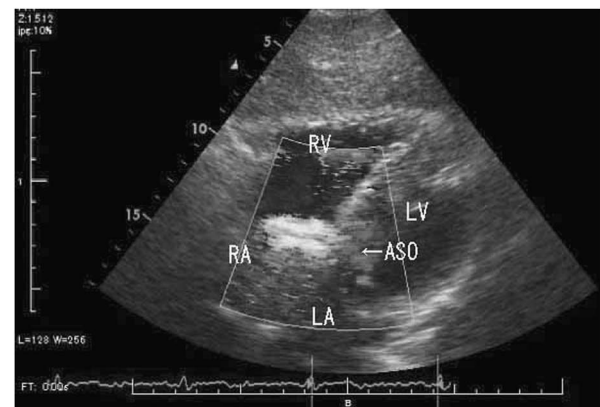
Transthoracic echocardiogram showing the ASO with vertically-tilted to the atrial septum because of the displacement due to fragility and hypermobility of the atrial septum. RA = right atrium; RV = right ventricle; LA = left atrium; LV = left ventricle; ASO = Amplatzer septal occluder.*
